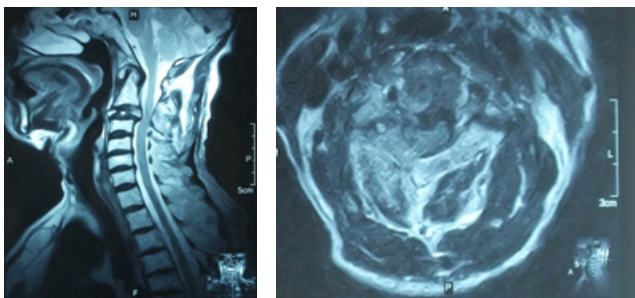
A&B: MRI of the cervical spine revealed an expansile lesion in C2-C3 vertebral level with pathological fracture of C2 lamina.
